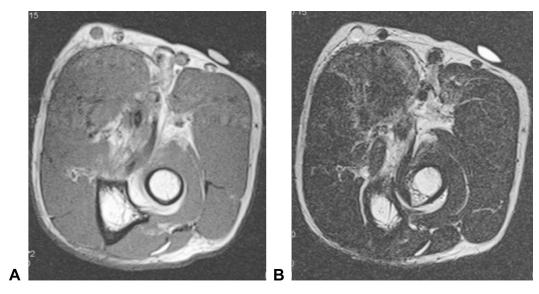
Preoperative magnetic resonance images of the left forearm, showing a partial high-intensity area on (A) T1- and (B) T2-weighted images in the flexor muscle compartment.
